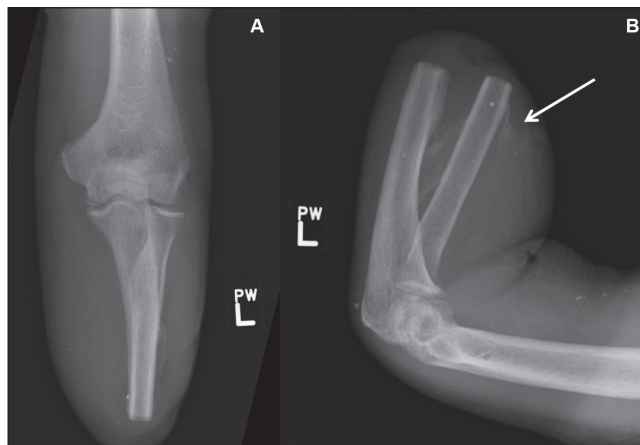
X-ray image of the left residual limb. A Anterior-posterior image with no soft tissue abnormality, and evidence of bony growth between the proximal ulna and radius. B Lateral x-ray image displaying a bony bridge between the proximal ulna and radius as well as osseous growth adjacent to the radius in the soft tissue indicative of heterotopic ossification (arrow)
